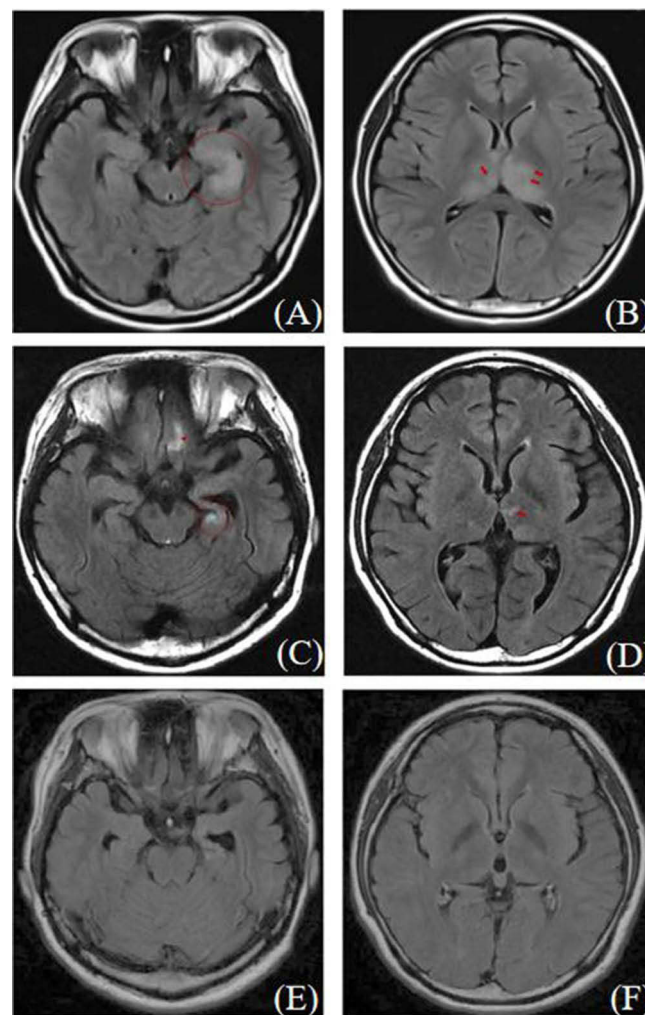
Longitudinal brain MRI changes in a patient with GFAP-A treated with tocilizumab. (A and B) Pre-treatment T2 Flair imaging shows bilateral thalamic swelling (red arrow) and abnormal signal lesions in the left hippocampus (red circle). (C and D) After the second tocilizumab treatment, T2 Flair imaging reveals reduced abnormal signal lesions in the bilateral thalamus (red arrow) and left hippocampus (red circle), with abnormal signals in the orbital gyrus (red triangle). (E and F) After the fifth tocilizumab treatment, T2 Flair imaging demonstrates near disappearance of bilateral thalamic abnormal signals, left hippocampal atrophy, and reduced orbital gyrus abnormalities.
